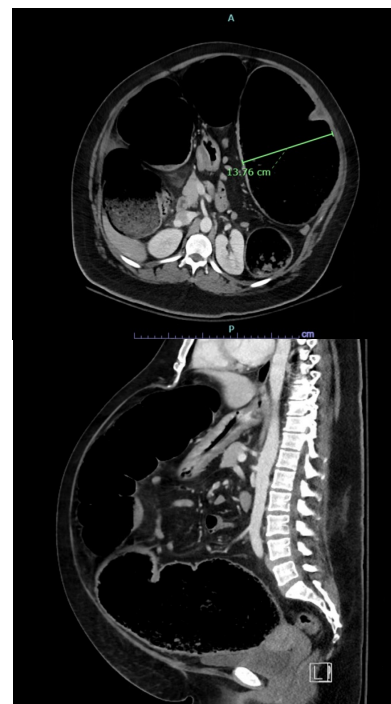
Pre-operative CT showing continued distension and new pneumatosis in the ascending colon
